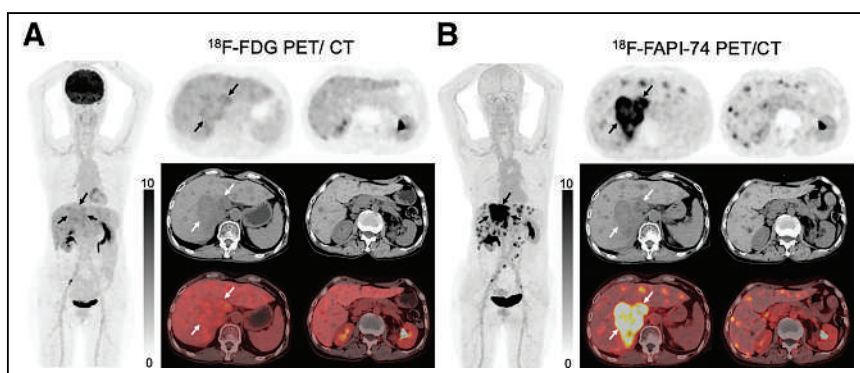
Representative case of metastatic liver cancer (intrahepatic cholangiocarcinoma). (A) 69-y-old woman with pathologically confirmed intrahepatic cholangiocarcinoma underwent initial staging using ^{18}F -FDG PET/CT, which shows low to moderate radiouptake in primary tumor (arrows). (B) ^{18}F -FAPI-74 PET/CT shows intense radiotracer uptake in primary lesion (arrows) and more intrahepatic metastases with intense uptake.
